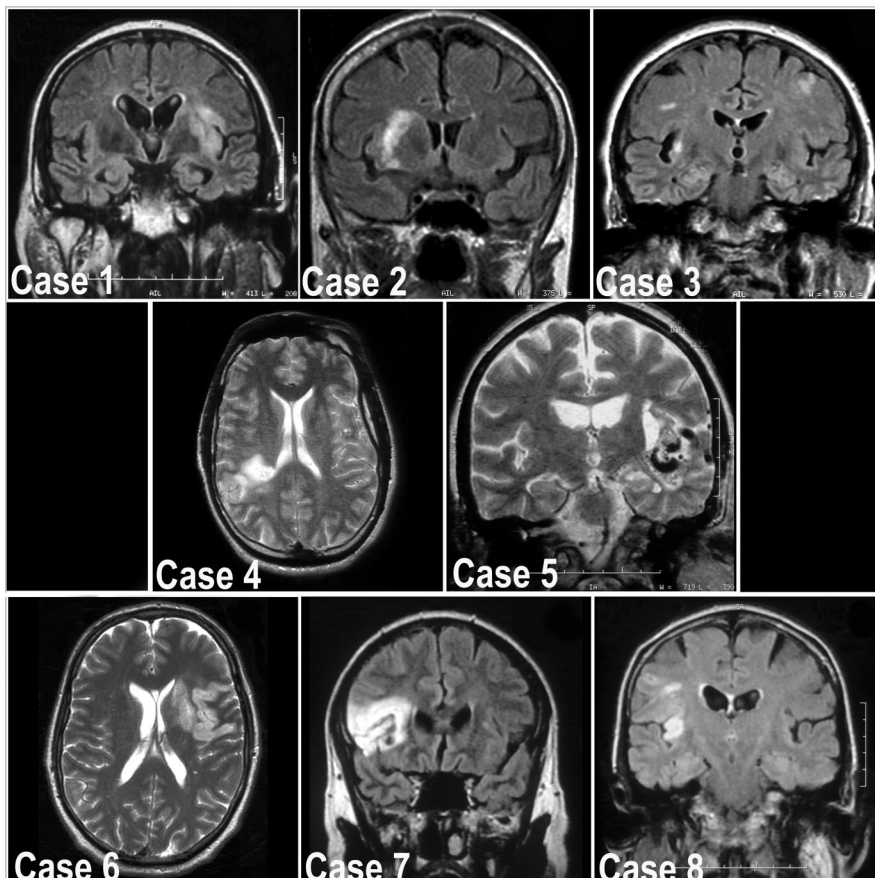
Fast spin echo (T2-weighted) TR 6,000 milliseconds, TE/EF 106, axial (Cases 1 and 5) and coronal acquisition (Case 2) images. Fluid-attenuated inversion recovery, TR 10,000 milliseconds, TI 2,500, coronal acquisition images (Cases 3, 4, 6, 7, and 8).
